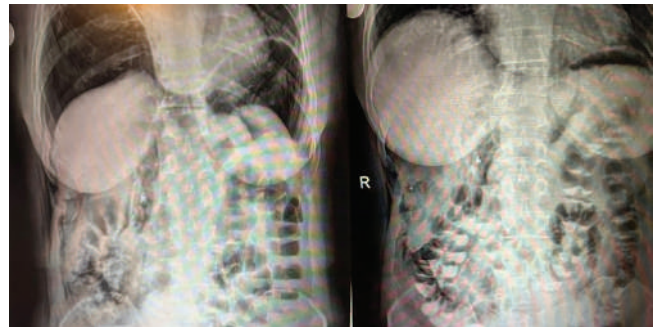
(A) Post-procedure upright abdominal radiograph, (B) Upright abdominal radiograph taken 1st and 3rd days.
